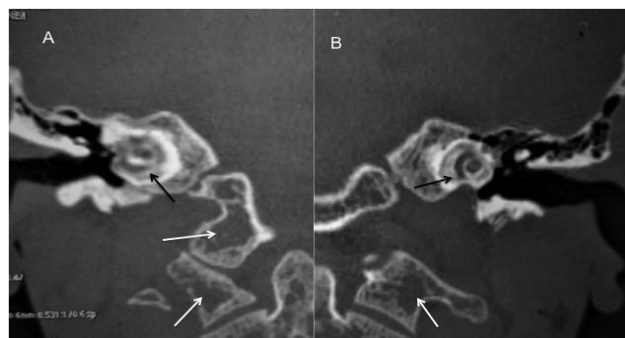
Coronal reconstructed computed tomography (CT) images of (A) right and (B) left temporal bones show ill-defined areas of reduced density in the pericochlear bony otic capsule (black arrows). Note is also made of marked diffuse osteoporotic changes (white arrows).
